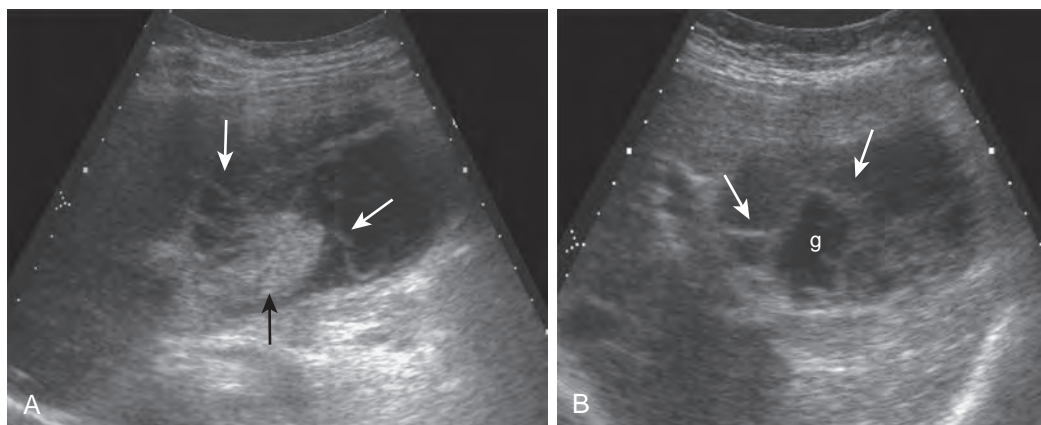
Acute gangrenous cholecystitis: ultrasound features. A. Sagittal image demonstrates echogenic, nonshadowing intraluminal material indicating aggregates of sludge (black arrow). Curvilinear intraluminal echogenic regions (white arrows) represent intraluminal membranes secondary to sloughed mucosa. B. Transverse image demonstrates intraluminal membranes (arrows) in gallbladder (g) lumen.
